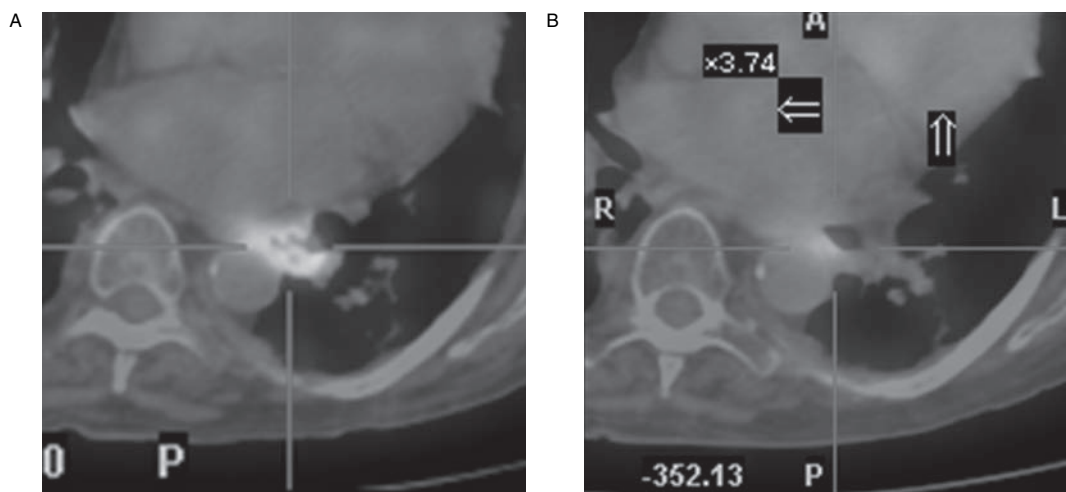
Response to neoadjuvant CRT of a cT3N1 ACA of the distal esophagus as assessed by CT-PET. A. Pretreatment axial image with maximum SUV of 6.6 at the primary tumor site. B. corresponding image 4-week posttreatment with reduction in SUV to 3.1. The patient was found to have a pCR at esophagectomy.
